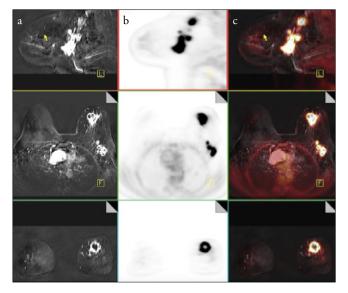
a-c. Mass lesions with 18F-FDG involvement connected to heterogeneous-enhanced high metabolic activity in the upper-inner and upper-outer quadrant axillary tail of the left breast in the fat-suppressed post-contrast (a), PET (b), and PET/MRI fusion images (c)
